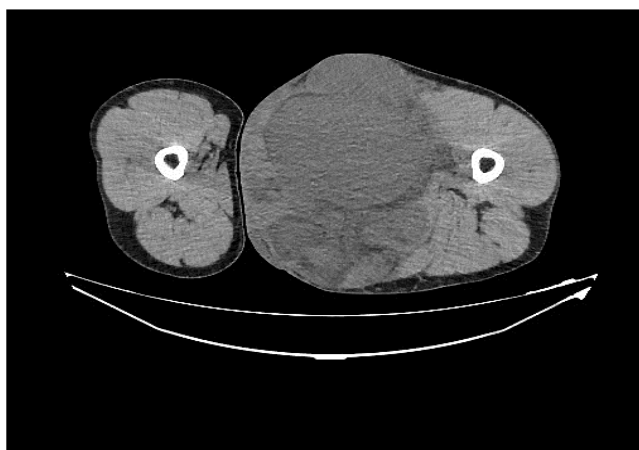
Axial CT-scans: Large lesion in medial and anterior left thigh compartment.
